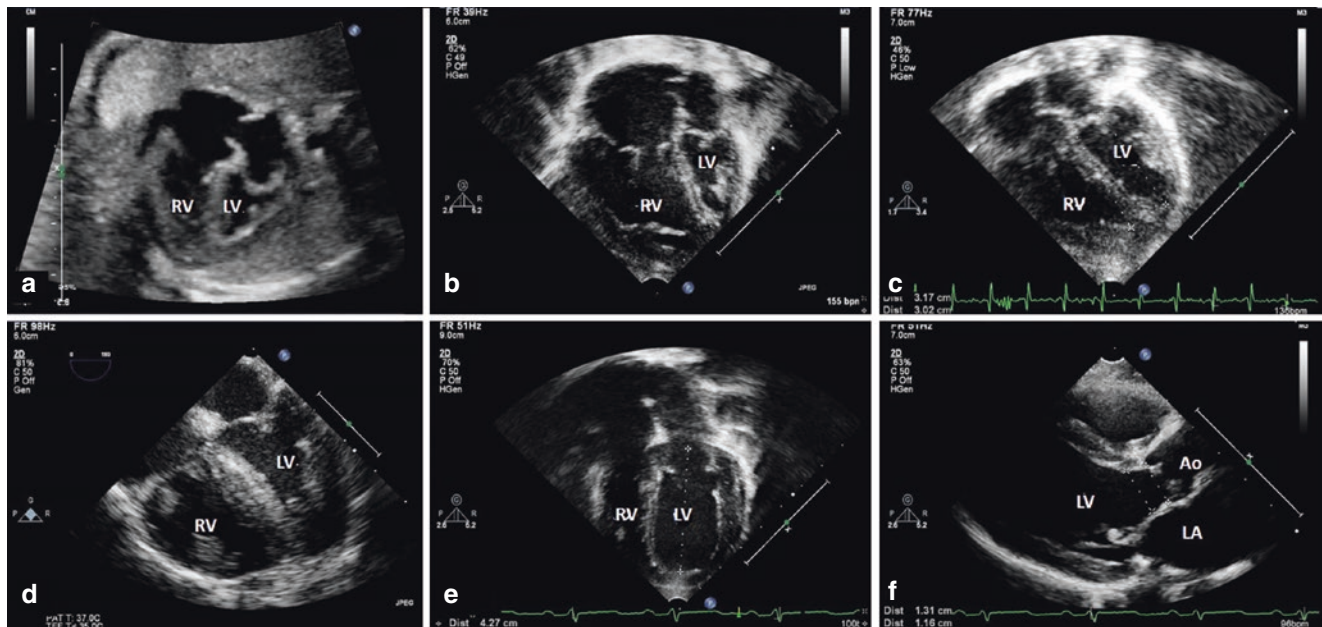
Staged rehabilitation of the left ventricle in a fetus with critical aortic stenosis. Echocardiographic progression. (a) Echocardiographic assessment at 27 weeks gestational age before fetal aortic valvuloplasty. The LV is already small (LV length Z-score -2.7) and dysfunctional. Maternal oxygen was given to the mother for 2 weeks after valvuloplasty. (b) Significant improvement of the LV size is seen after birth. The neonate underwent a hybrid procedure with bilateral pulmonary artery banding and stent implantation in the arterial duct followed by atrial septostomy. (c) At 6 months of age, there is
